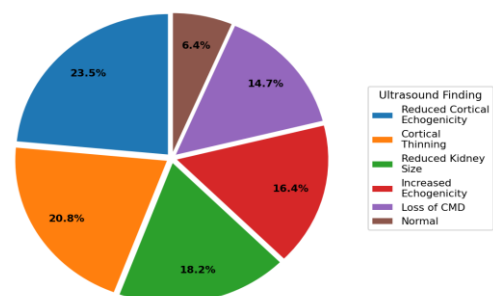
Distribution of ultrasonographic abnormalities detected in the CKD cohort (n = 360). Reduced cortical echogenicity was the most frequently observed abnormality.
